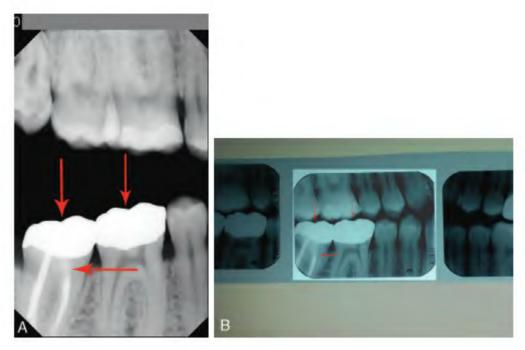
The comparison of postmortem to antemortem radiographs for identification confirmation. The red arrows in (a) and (b) show numerous points of concordance of the crowns and root canal.
